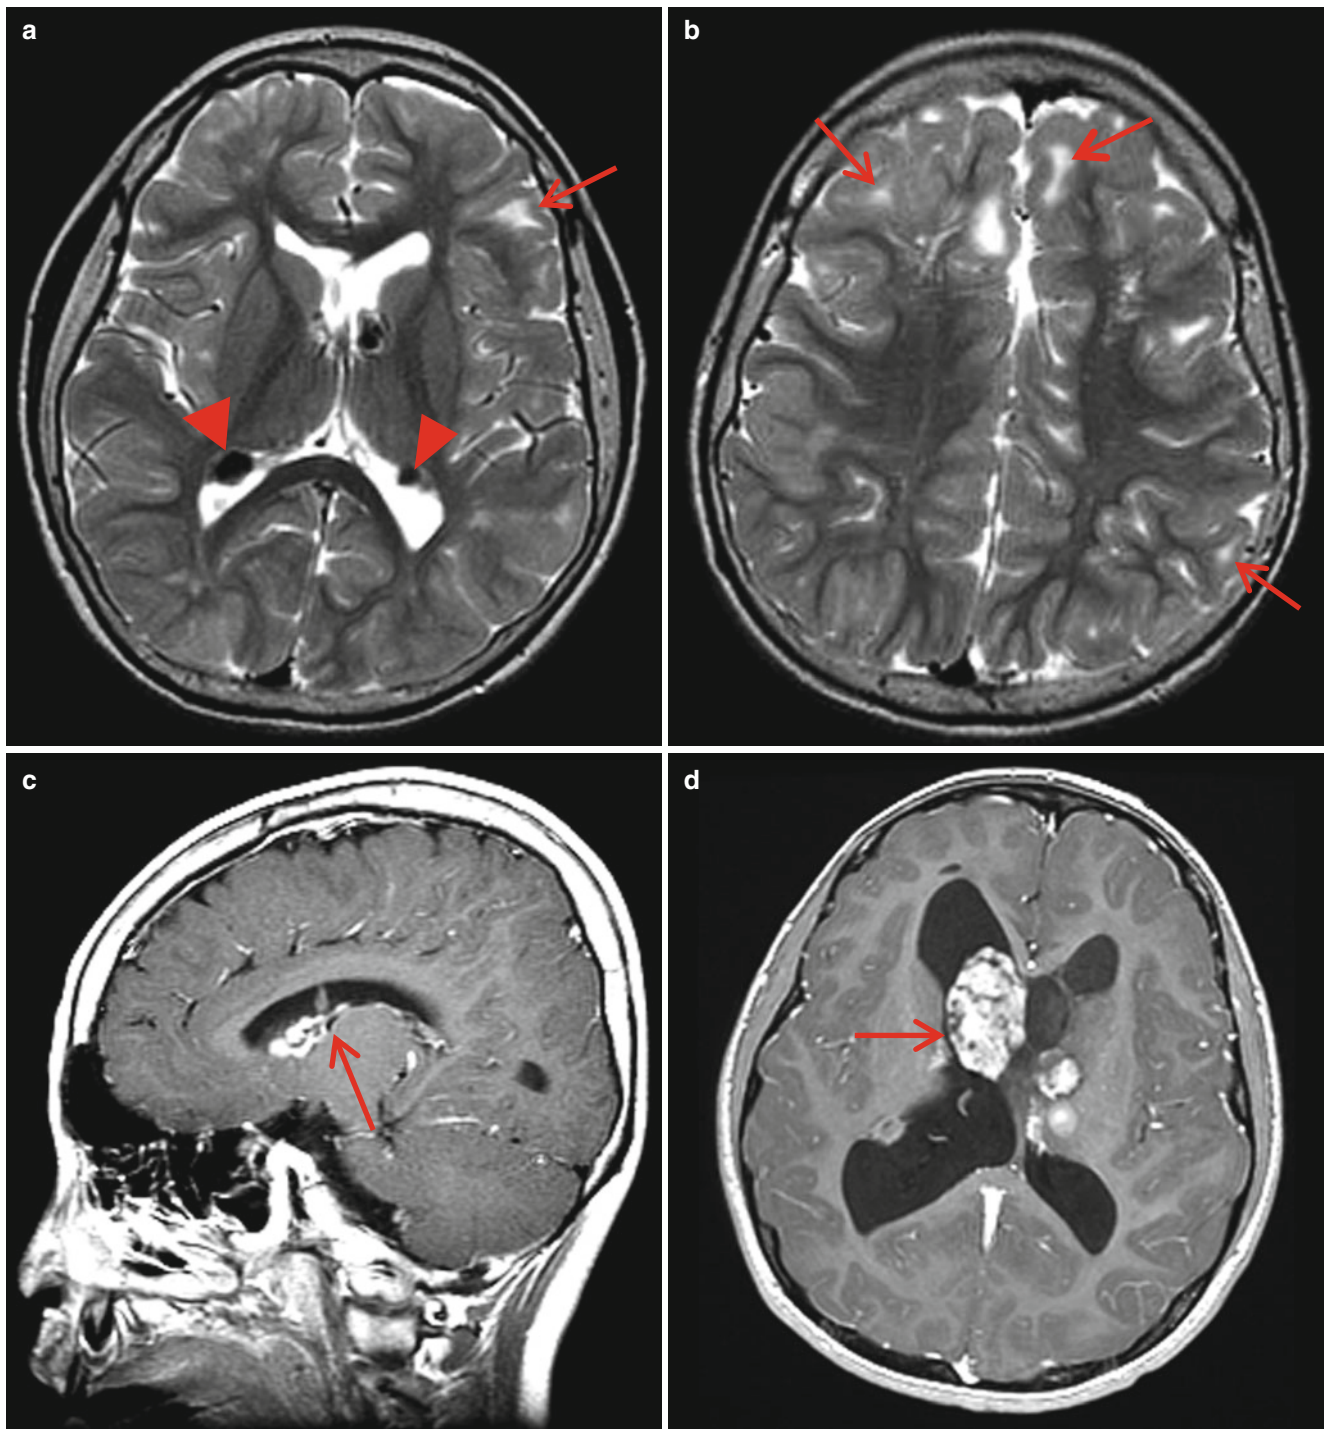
Tuberous sclerosis. (a, b) T2-weighted image shows multiple subependymal tubers (*arrowheads*) along the wall of the lateral ventricles. The low signal intensities are due to calcifications. Cortical tubers (*arrows*) show multiple subcortical high signal intensity lesions with gyral expansion (*arrow*). (c) Postcontrast sagittal image shows
